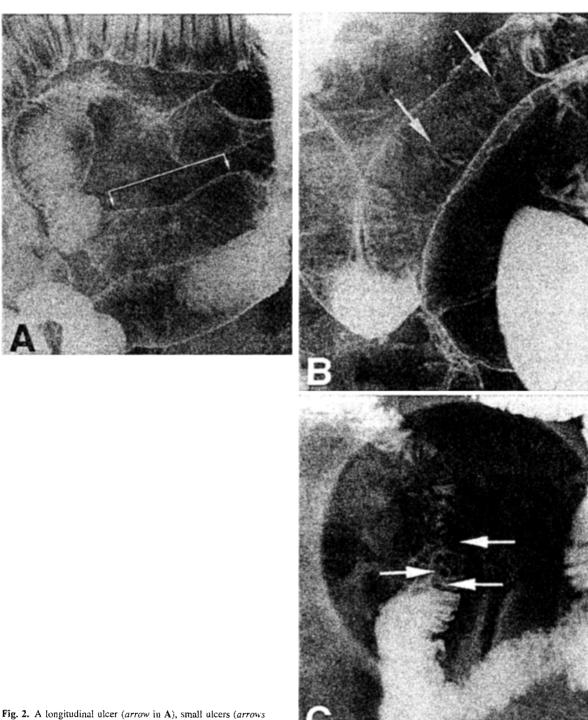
A longitudinal ulcer (arrow in A), small ulcers (arrows in B), and inflammatory polyps (arrows in C) are demonstrated by preoperative radiography of the small intestine.
